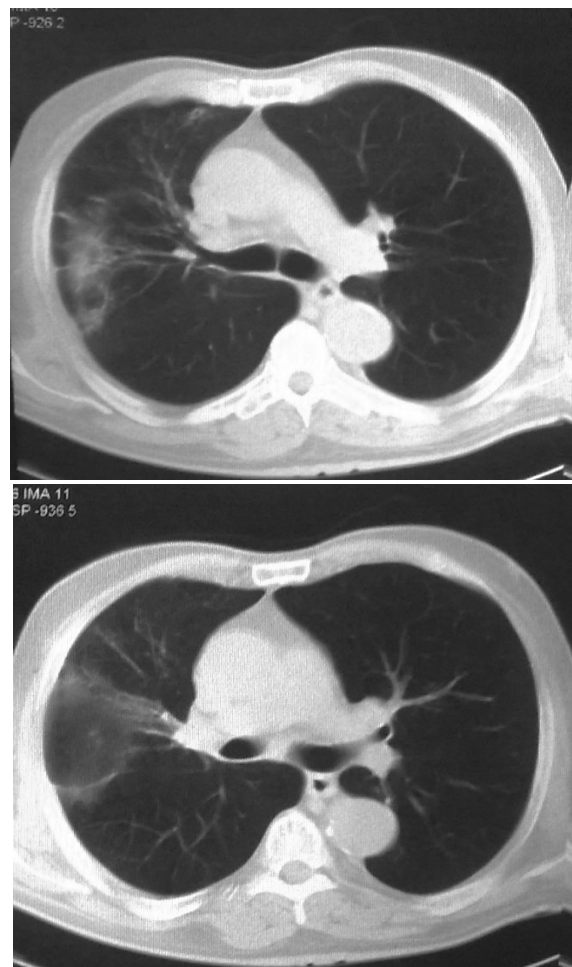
Chest computed tomography 2 months after admission showed ground glass opacities
